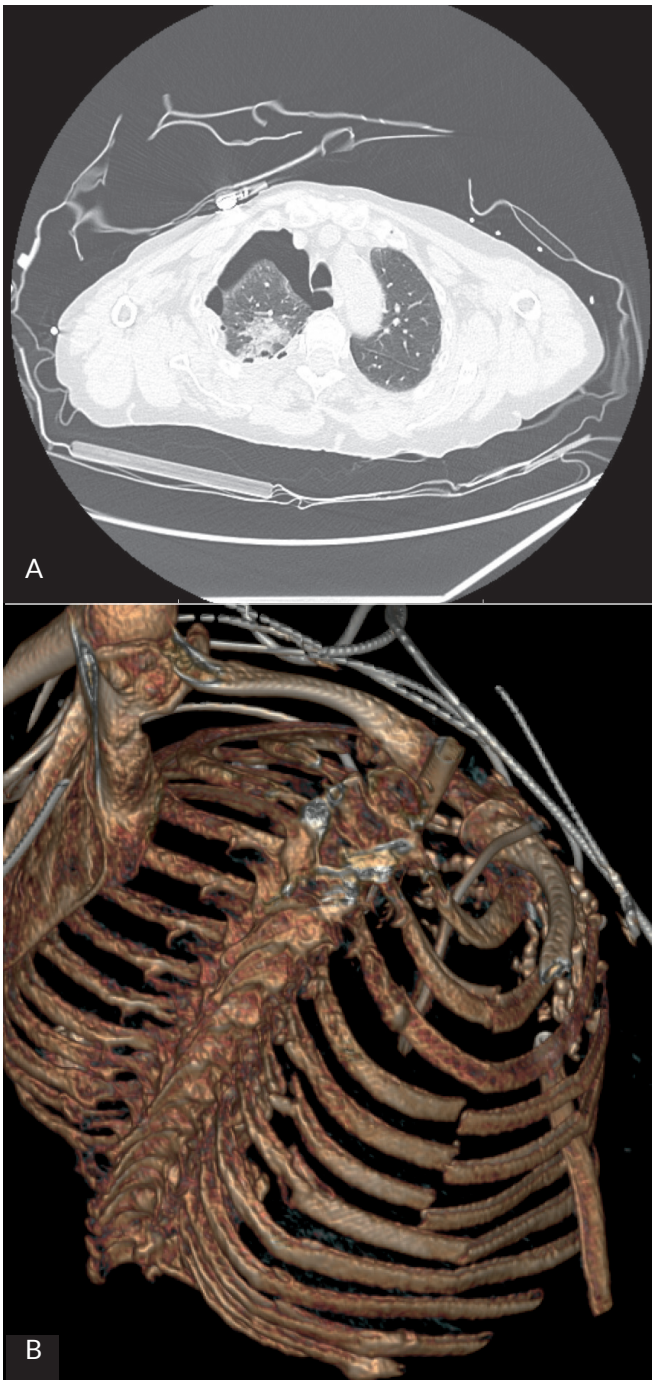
Case 5. Computed tomography findings. A. preoperatively. B. postoperatively
